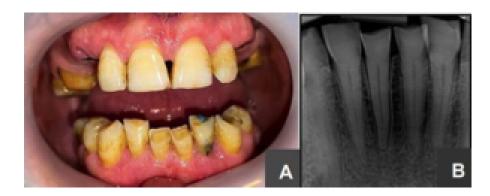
A) Clinical aspect; B) Periapical radiograph, anterior teeth with attrition and partial calcifications in the root canal system.
